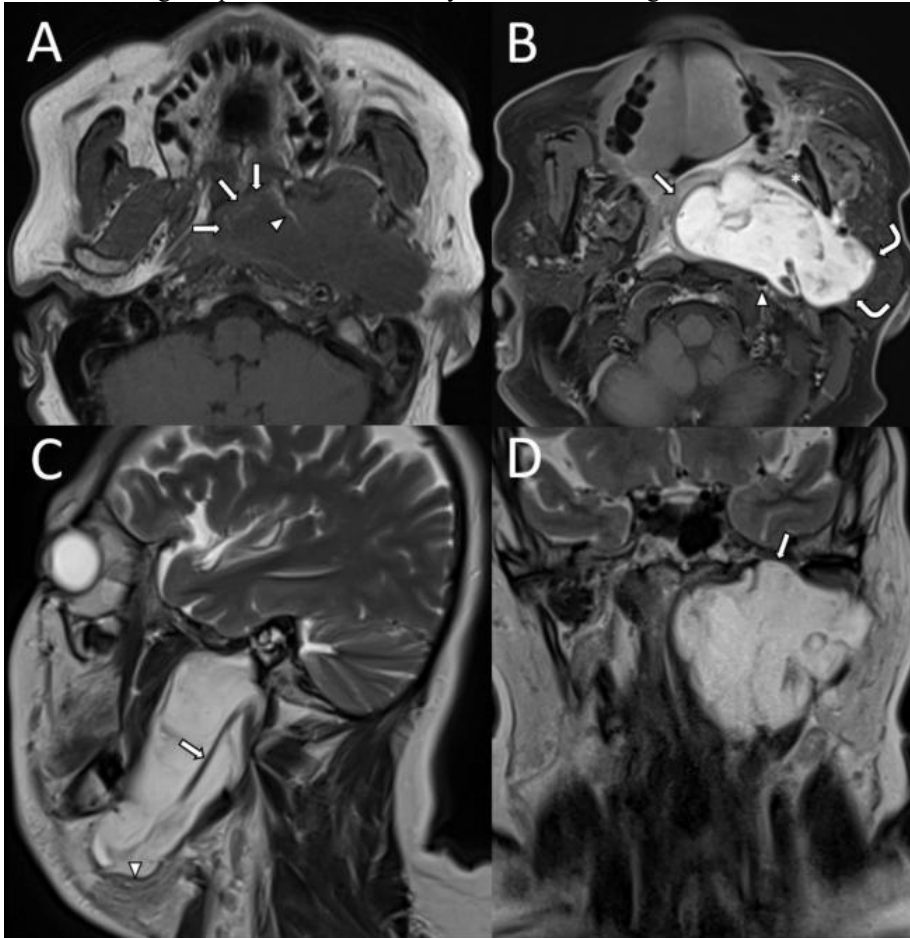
Left parapharyngeal space pleomorphic liposarcoma with myxoid features. (A) Axial T1-weighted non-contrast image at the level of the hard palate shows a large mass centered in the left parapharyngeal space. Note the relative lack of fat along the anteromedial border of the mass (arrows), implying that the mass is arising from the parapharyngeal space, not the parotid space. Notably, a small amount of fat along an intratumoral septum is present (arrowhead). (B) Axial T1-weighted fat-suppressed post-contrast image just inferior to (A) shows mass lobulations with diffuse enhancement and anteromedial displacement of the pharyngeal space (arrow), anterior displacement of the masticator space (asterisk), slight posterior displacement of the internal carotid artery (arrowhead), and abutment of the deep parotid gland (curved arrows), which was invaded on surgical pathology. (C) Sagittal T2-weighted image along the long axis of the mass demonstrates high signal of the mass with encasement of the stylohyoid ligament (arrow) and abutment of the left submandibular gland (arrowhead), which was not invaded on surgical pathology. (D) Coronal T1-weighted post-contrast image shows superior extension of the mass to the skull base at the level of the foramen ovale (arrow).
